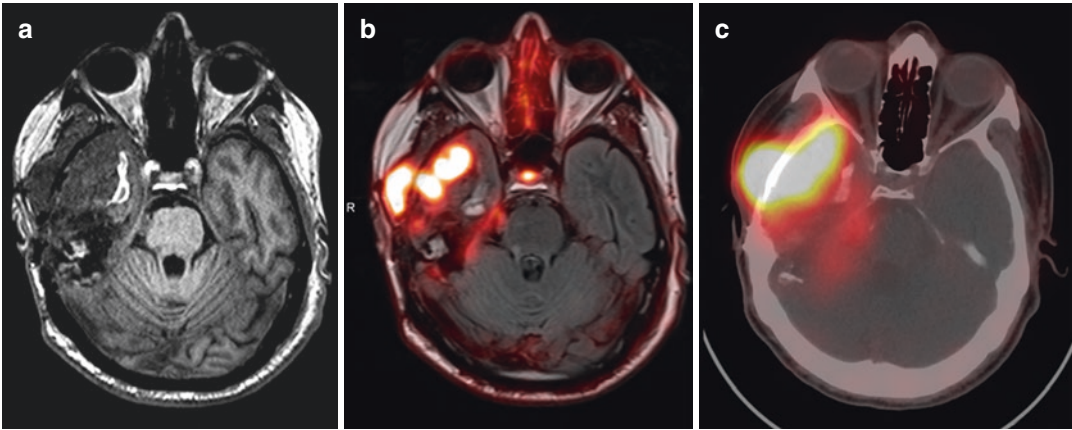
54-year-old male with a recurring anaplastic meningioma underwent a PET/MR scan performed on the Siemens 3T PET-MR. (a) Shows the T1_MP-RAGE image of the multilobulated tumor in the right middle cranial fossa. (b) Shows there is intense Ga-68 Dotatate uptake in the tumor with max SUV equal to 17.23. The
